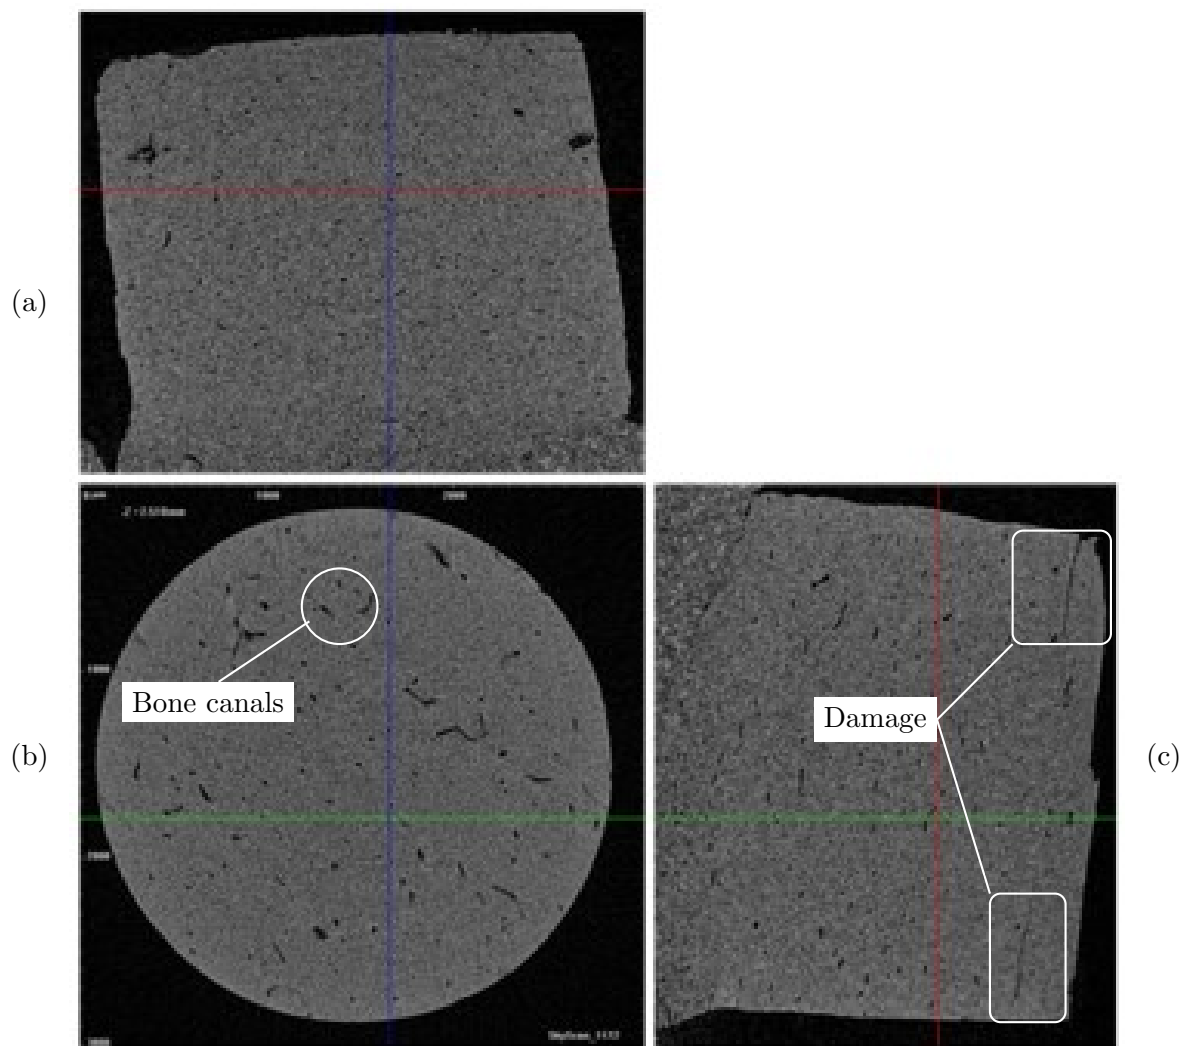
3rd angle projection of the μ CT image of the recovered biopsy
